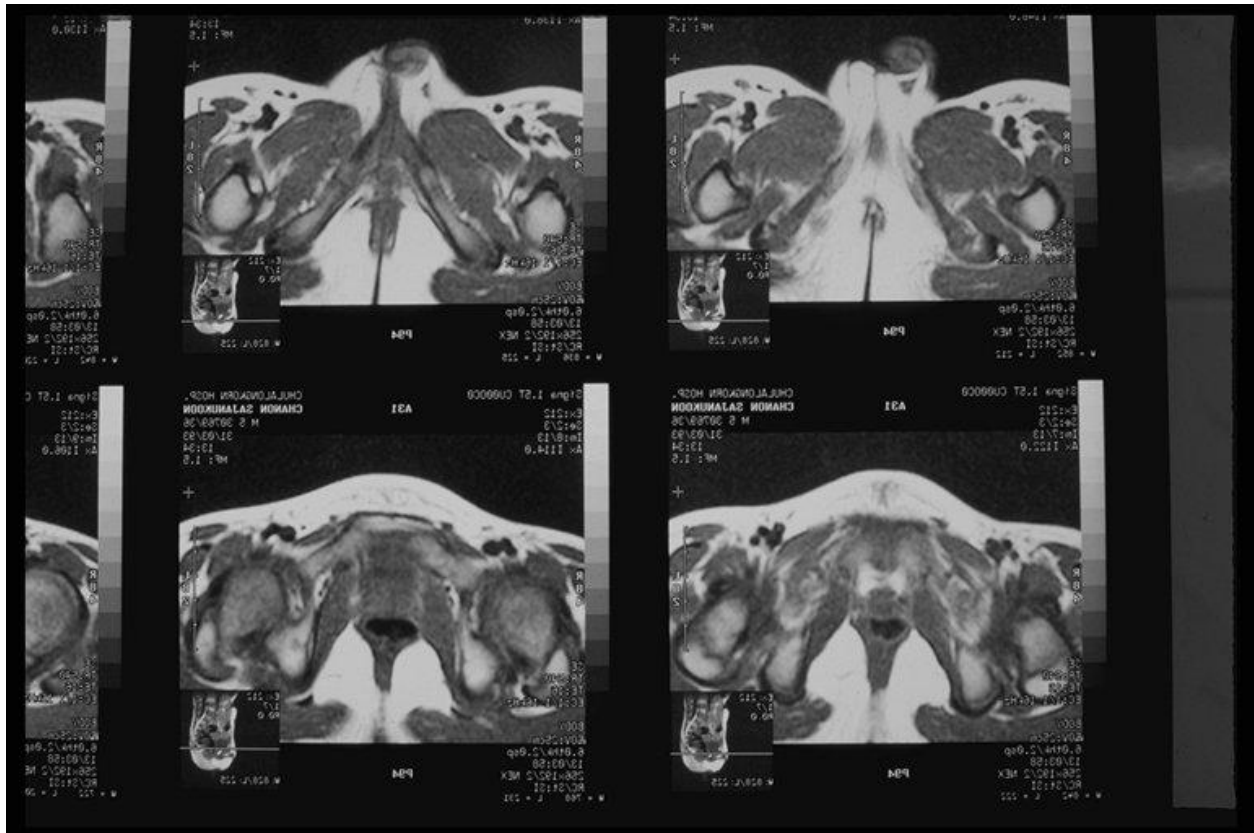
MRI image showing undescended testis
